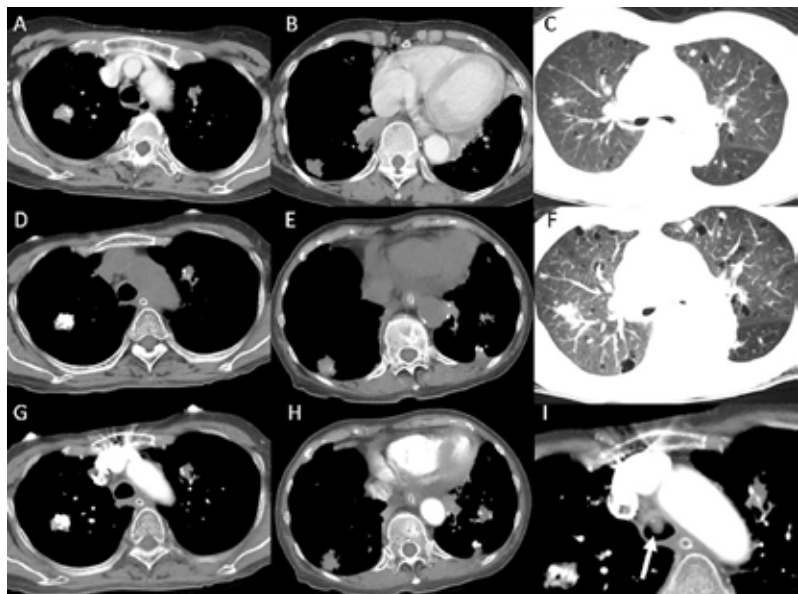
(A) (B) and (C) Two years before this admission, a computed tomography scan of the chest revealed bilateral basal consolidations, cystic lesions, and diffuse lung nodules, some of which were partially calcified. (D) (E) (F) (G) and (H) Unenhanced and enhanced chest CT scans at this admission revealed enlarged nodules, calcifications, consolidations and cystic lung lesions. (I) An endotracheal lesion (arrow).
